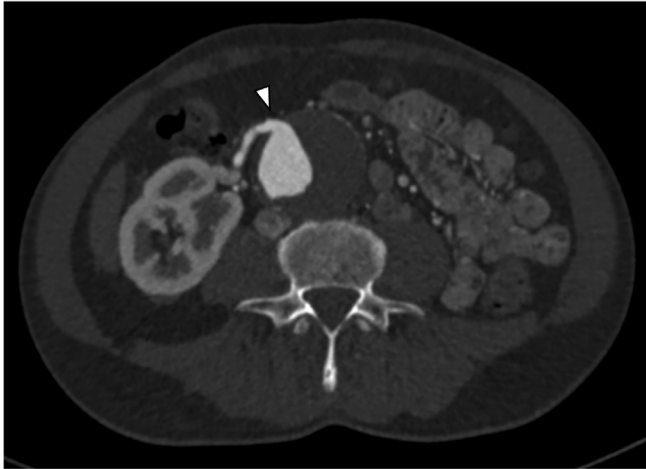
Axial image of the preoperative computed tomography angiogram, showing the origin of the “main” renal artery (RA) arising from the right antero-lateral aneurismatic abdominal aorta (*arrowhead*), perfusing the cross-fused renal ectopia (CFRE).
